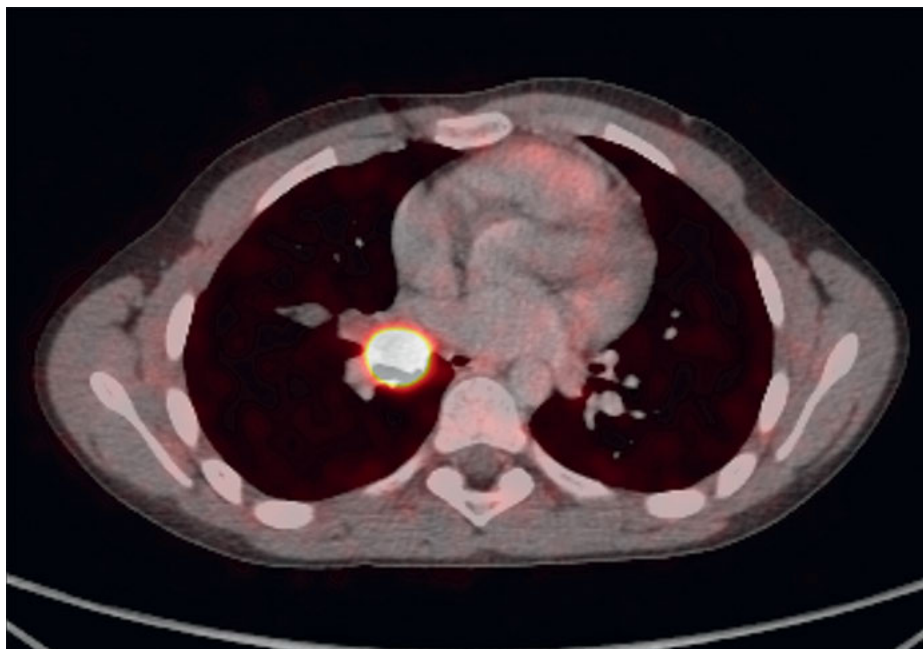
PET/CT scan of an typical carcinoid of the right lower bronchus.
